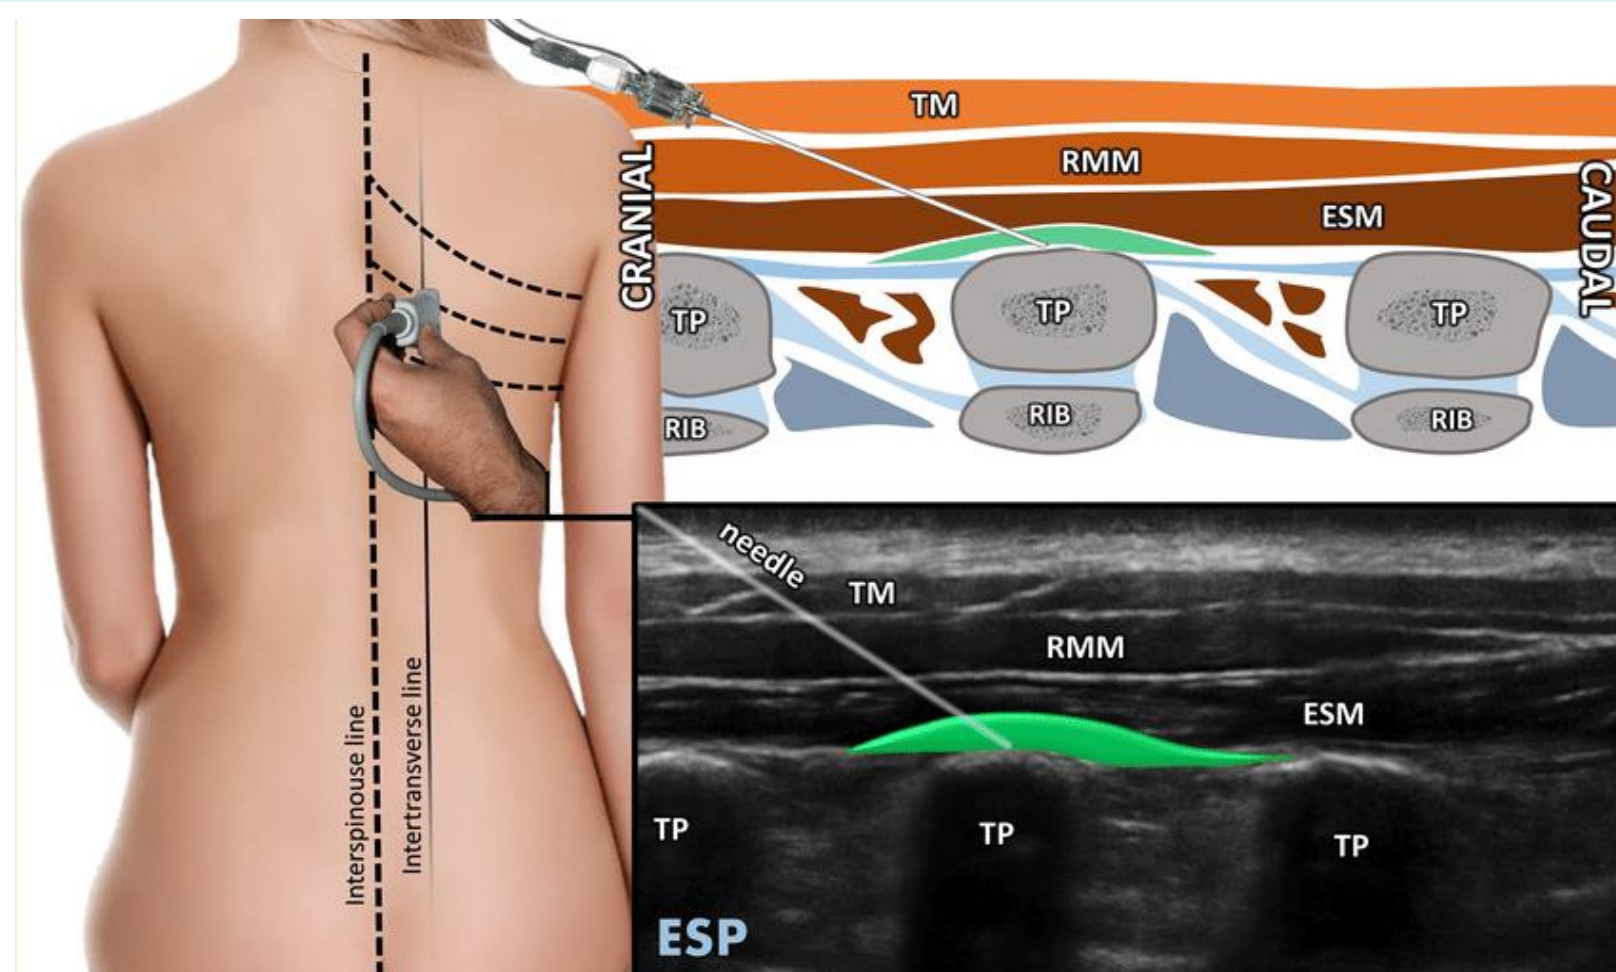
Anatomical location of ESP block and distribution of local anesthetic seen on ultrasound.
